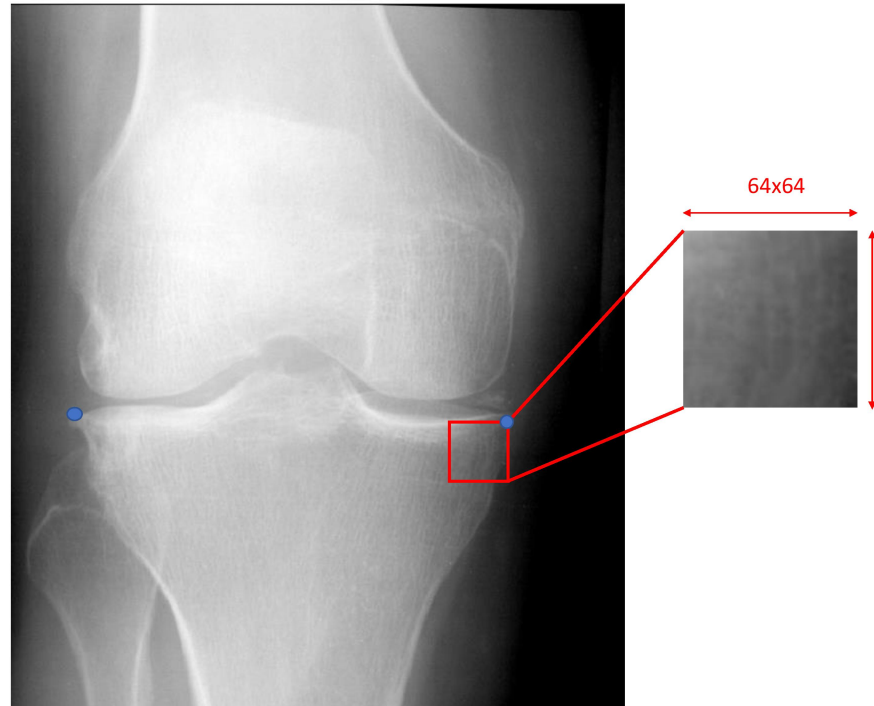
The figure presents the extraction of marginal region of interest (ROI) from medial tibia in plain radiographs
